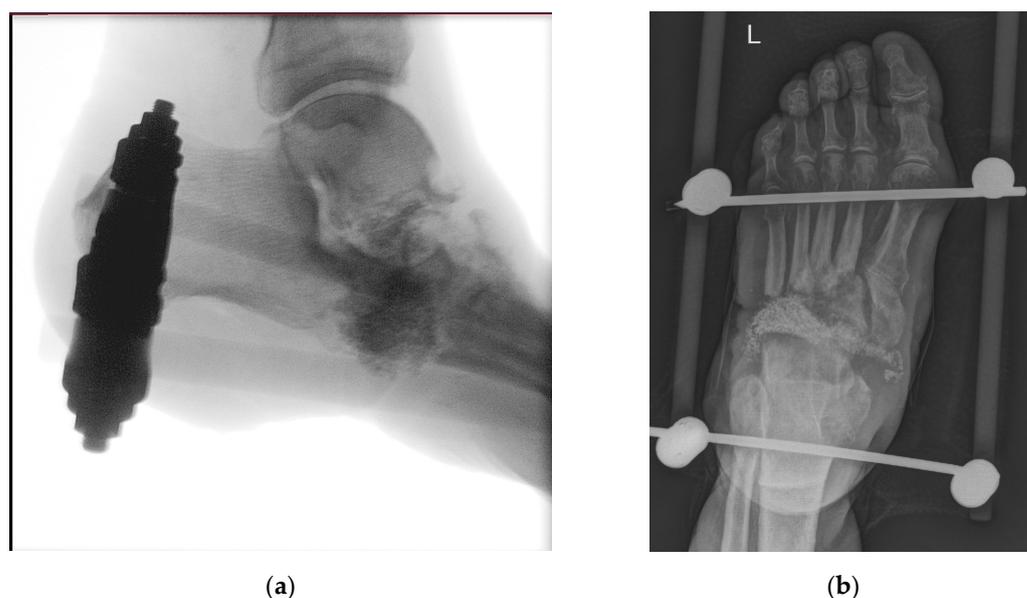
(a) Intraoperative X-ray—resection of cuboid bone, base of 4th and 5th metatarsal bones as well as head of talus due to osteitis, placement of bioactive glass granules, and an external fixator. Image captured intraoperatively with diascopy using Siemens Cios Alpha® (Siemens, Munich, Germany) (average exposition parameters: 52 kV, 0.03 mAs, and 7.5 fps); (b) patient three months after resection and bioactive glass insertion. Image captured with Philips Digital Diagnost® (Philips, Amsterdam, The Netherlands) (exposure parameters: 63 kV and 2 mAs).
